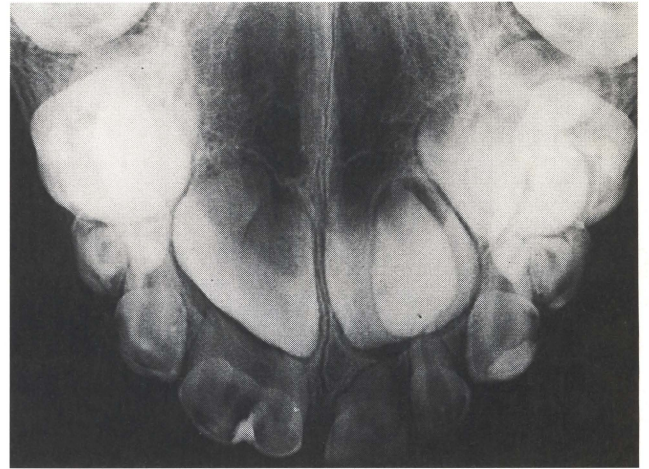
Nasoclusal radiograph of patient A. S. showing two-crown, two-rooted appearance of "double tooth" in site 51, 52 and probable fusion of the underlying permanent central and lateral incisors at this site. The left permanent central incisor appears to be larger than expected.
